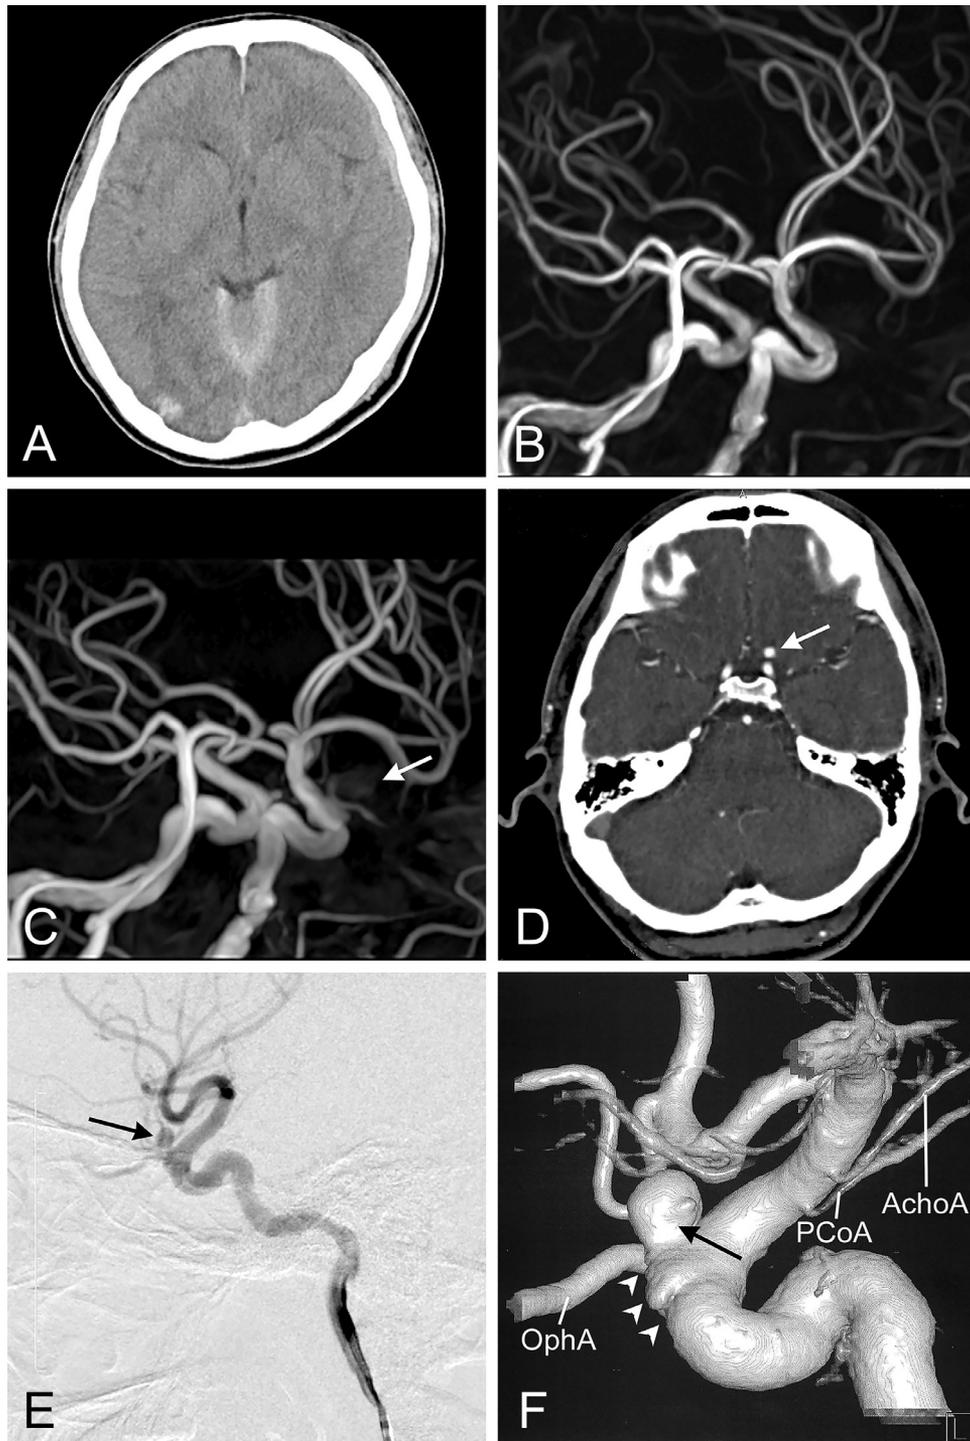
Images obtained from a 20-year-old man who has a motor vehicle accident and subsequent traumatic aneurysmal formation. (A) Initial head CT scan shows acute subdural hematoma at the left cerebral convexity and beneath the cerebellar tentorium, as well as contusional hemorrhage at his right occipital lobe. (B) Initial MR angiogram shows no intracranial aneurysm formation. (C) Repeat MR angiogram obtained 4 weeks after the motor vehicle accident shows aneurysmal formation at the left supraclinoid internal carotid artery (ICA). (D) CT angiogram also shows abnormal enhanced mass (arrow) adjacent to the left intracranial ICA. (E) A lateral view of left internal carotid angiogram. A saccular aneurysm (arrow) is seen at the supraclinoid segment of the left ICA. (F) 3D-rotational left internal carotid angiogram shows the saccular aneurysmal change (arrow) and irregular dilatation (arrowheads) on the supraclinoid ICA. The orifices of posterior communicating and anterior choroidal arteries are located just distal to the aneurysm. Abbreviations: AchoA, anterior choroidal artery; OphA, ophthalmic artery; PCoA, posterior communicating artery.
